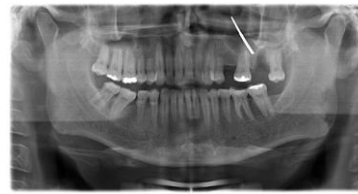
Orthopantomography image showing dental burr in maxillary sinus
